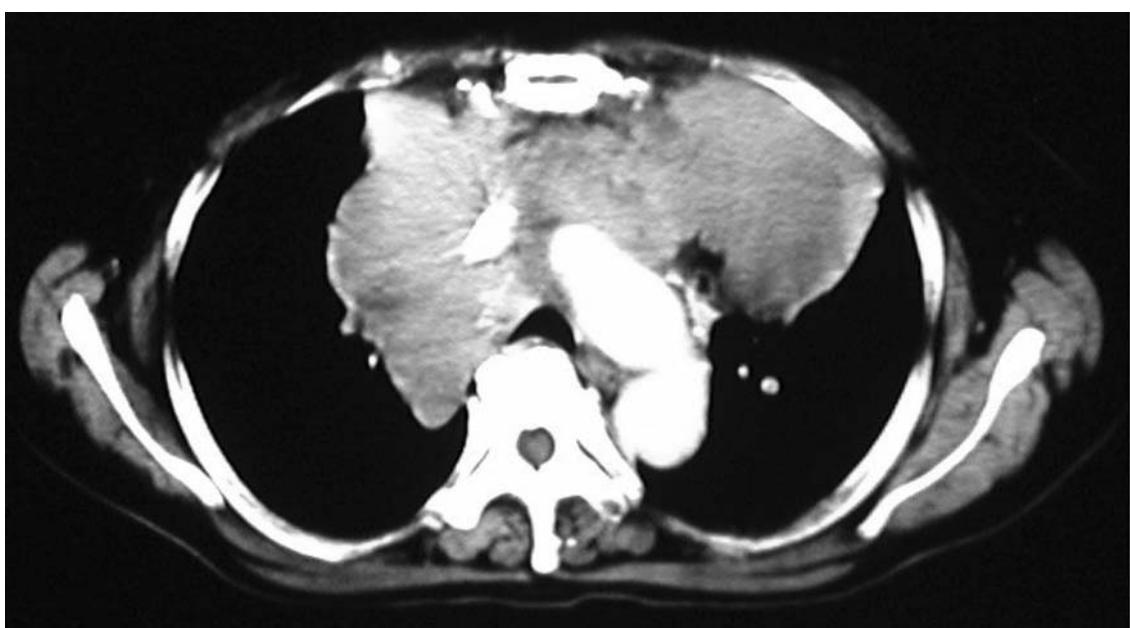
CT scan of the thorax. The initial CT scan of the thorax shows a large mass with low attenuation foci that suggests necrosis. The mass extended to the aorta and the opacification of the superior vena cava was decreased by the mass.
